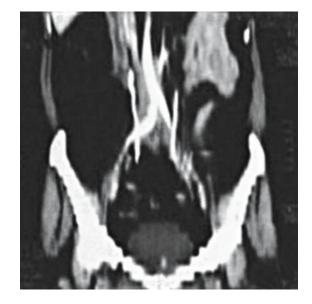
A CT urogram (reformatted) shows medialization of both ureters
